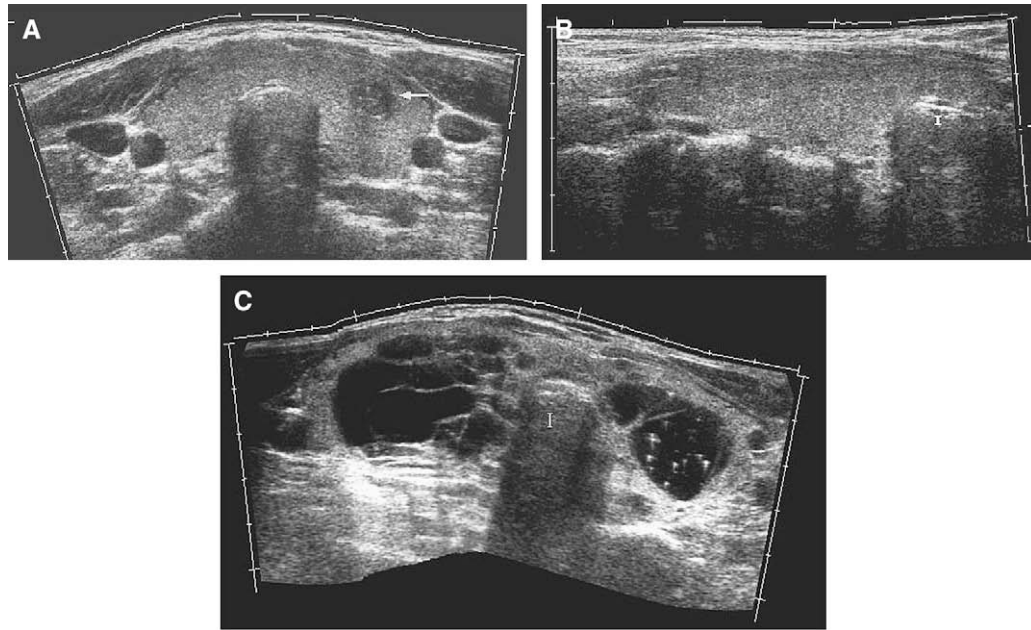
Transverse EFOV sonogram showing both thyroid lobes and isthmus in the same image, (A) allowing comparison of parenchymal textures of both lobes (arrow shows a nodule). (B) The longitudinal EFOV sonogram covering the whole vertical dimension of the hypertrophic lobe together with the isthmus facilitating the routine measurements. (C) Transverse EFOV sonogram of another thyroid gland showing multiple cystic nodules (t, isthmus).
